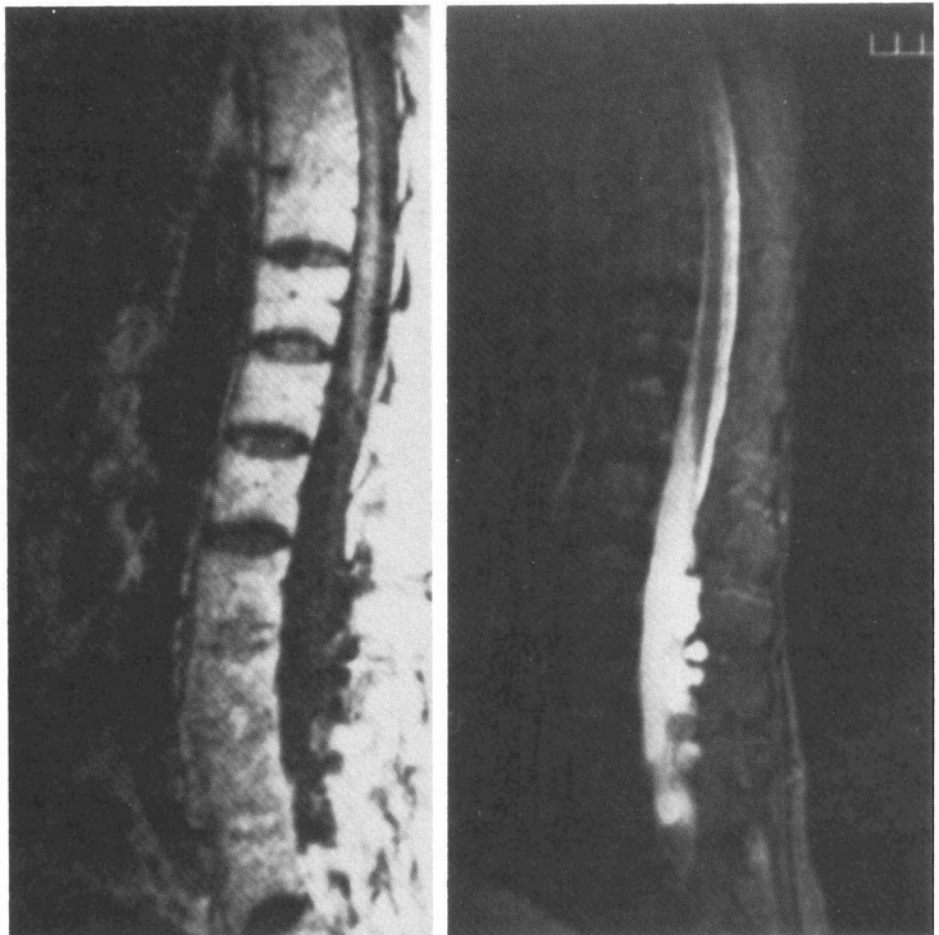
Sagittal T1-weighted (A) and T2-weighted (B) images show evidence of dural ectasia with posteriorly oriented diverticula. These diverticula are filled by CSF as demonstrated by a signal intensity similar to that of the dural sac.
